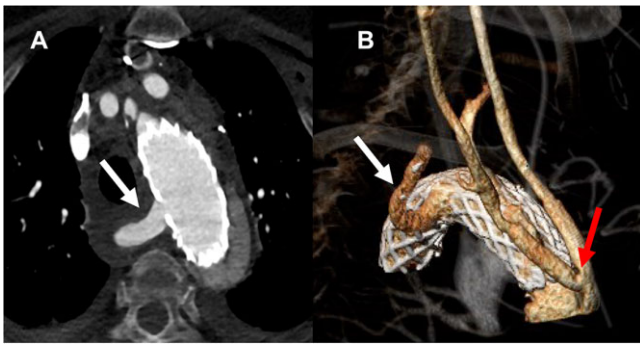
Postoperative computed tomography scan with axial plane (A) and 3-dimensional reconstruction (B) revealed unrestricted flow of the aberrant right subclavian artery out of the true lumen (white arrow). Computed tomography also showed regular perfusion of the common carotid arteries Y-anastomoses from the ascending aorta prosthesis (red arrow).
